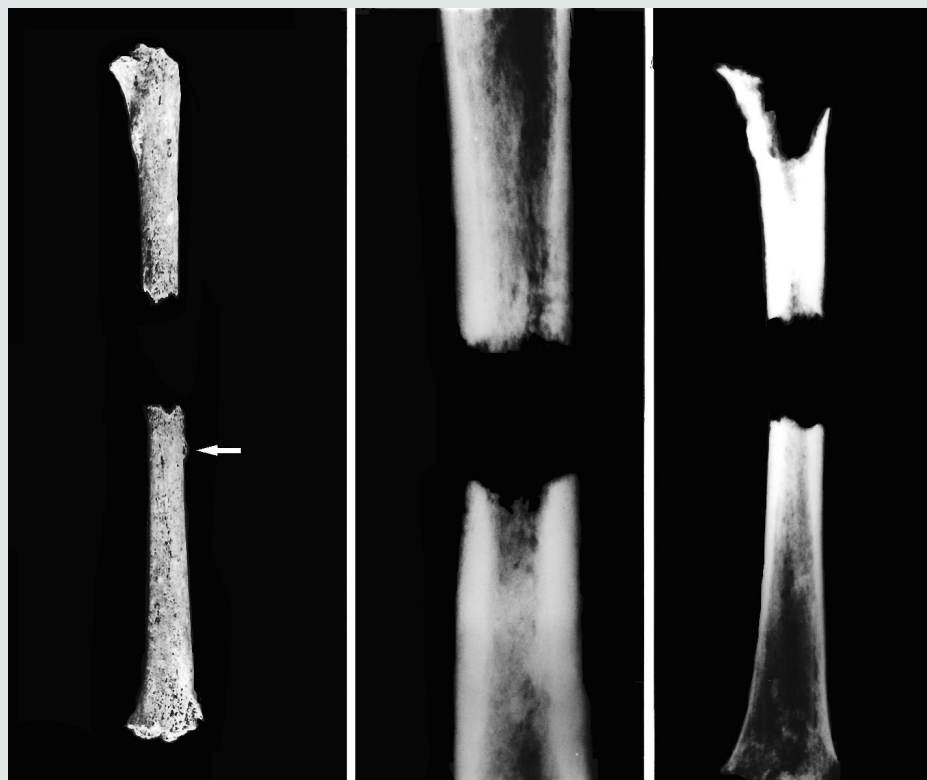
Left- Right femur of individual 6. The loss of bone substance replaced by the tumour probably matches the surface area between both fragments of diaphysis, at both ends there are many vascular orifices of neoplastic origin. The arrow indicates an area of tumour hyperostosis. Centre and right. X-rays of the right femur of Clunia 6. The ends of the injuries clearly show the changes of the bone that show secondary dome-shaped structures in reaction to the neoplasm.
